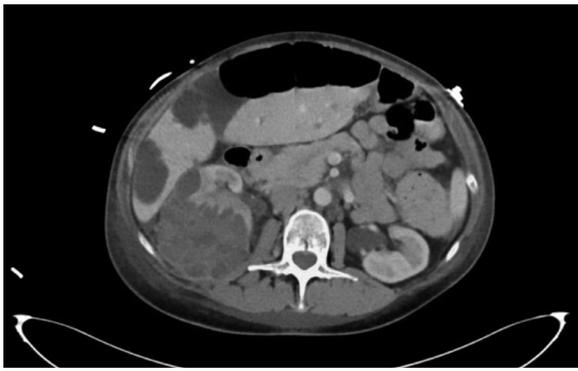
Initial CT with contrast. Large right complex renal cyst. Several liver masses, biopsied in the past, negative for malignancy.
